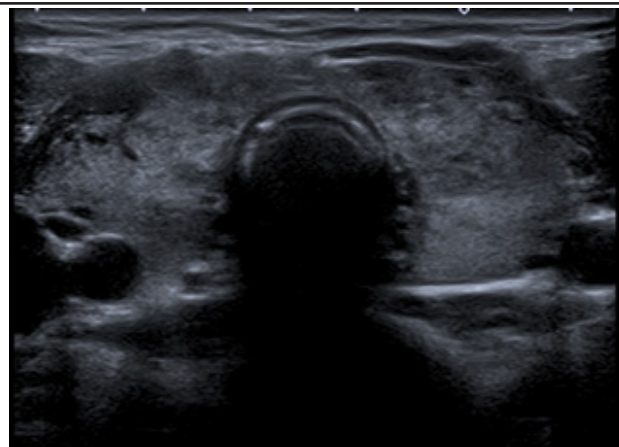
Preoperative neck ultrasound. Grayscale transverse image showing a bulky thyroid gland with coarse, heterogeneous, pseudonodular echotexture.
